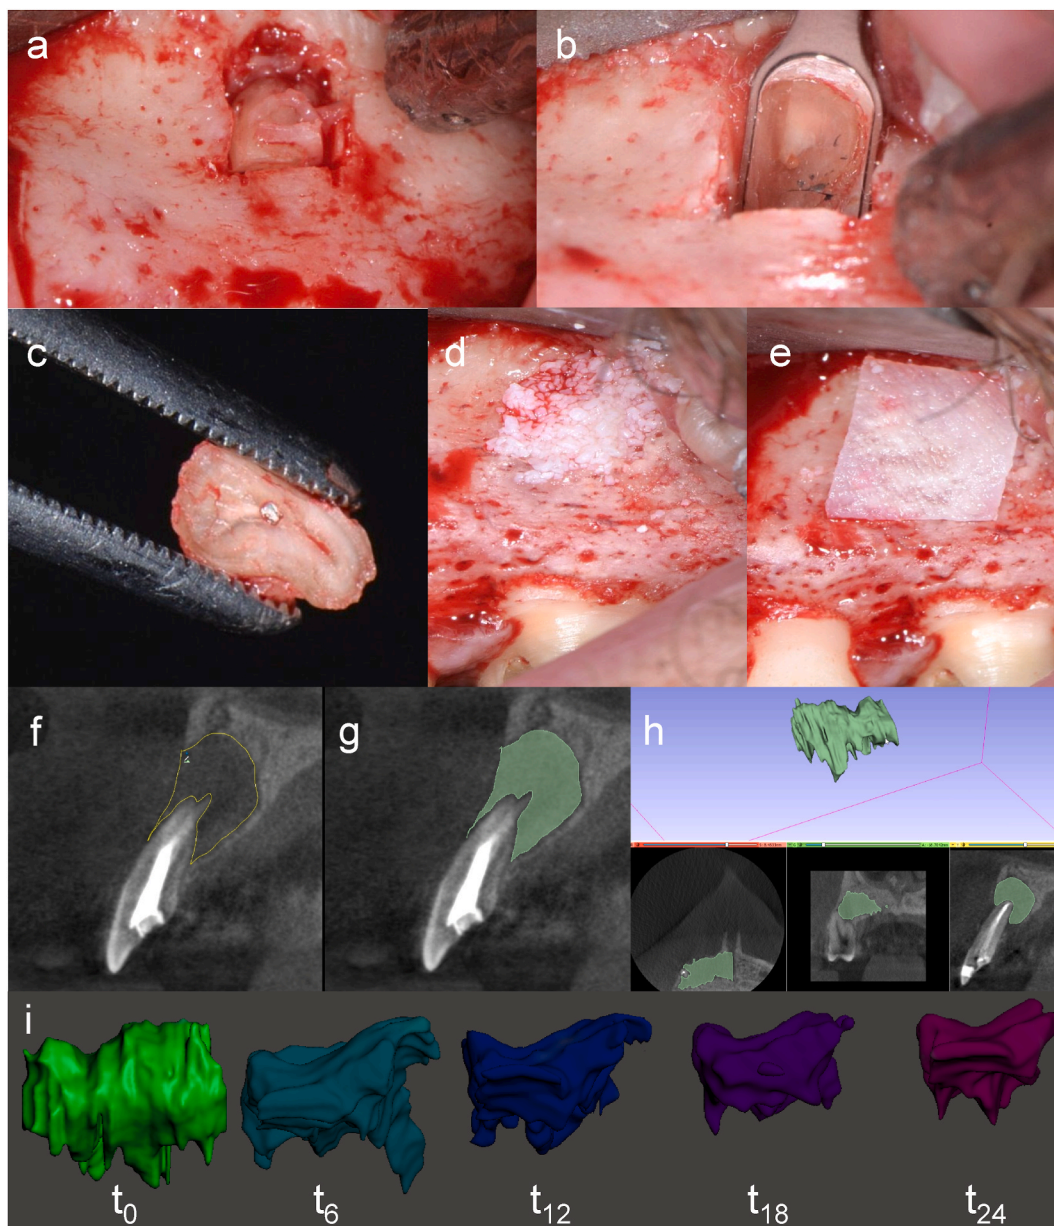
The apical surgery procedure with placement of fascia lata membrane and lyophilized homologous bone powder. (a) Apical 3 mm osteotomy and dissection. (b) The remaining root was sectioned, and (c) sectioned apex. (d) Bone substitute placement. (e) Membrane placement. (f) The initial Cone-Beam Computed Tomography was used to set the lesion border limit (green border), (g) to estimate the lesion area with a lesion segmentation process in a sagittal view depicted in green, and complete lesion volume assessment, using a composition image with multiplanar and three-dimensional visualization of the lesion using additional angles (3D Slicer v4.11). (h) Three-dimensional visualization of the lesion that (i) estimated volume evolution at 0, 6, 12, 18, and 24 months (Autodesk Meshmixer). (For interpretation of the references to color in this figure legend, the reader is referred to the Web version of this article.)
